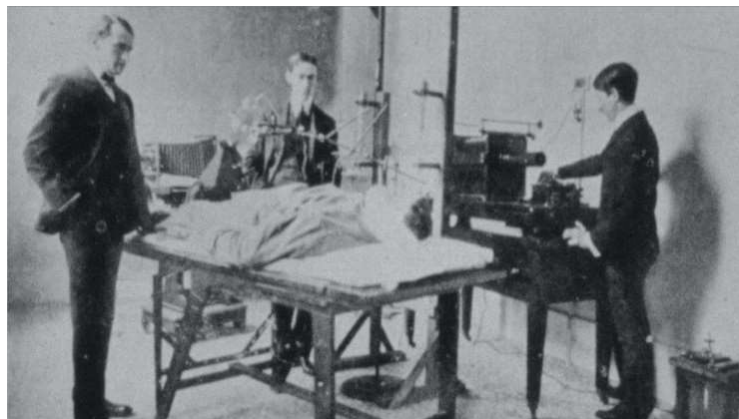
Wilhelm Roentgen discovers the X-Ray.
